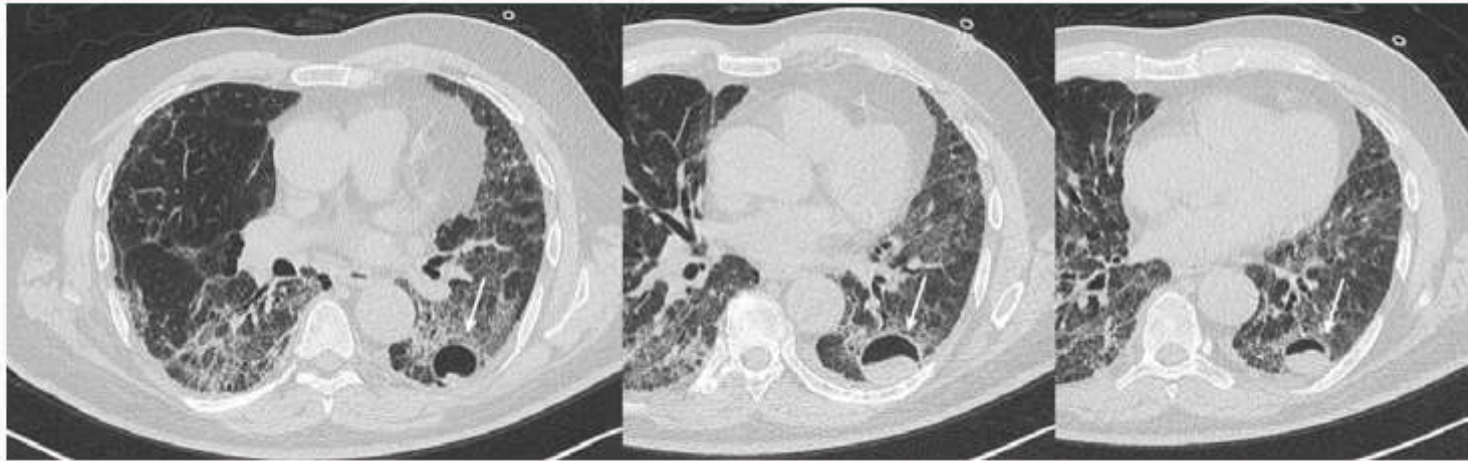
Axial thin-sections unenhanced CT scan show diffuse bilateral confluent and predominantly linear ground-glass opacities with a pronounced peripheral and posterior distribution and in lower left lobe a cavitated area with mucoid component in the context (arrows).
